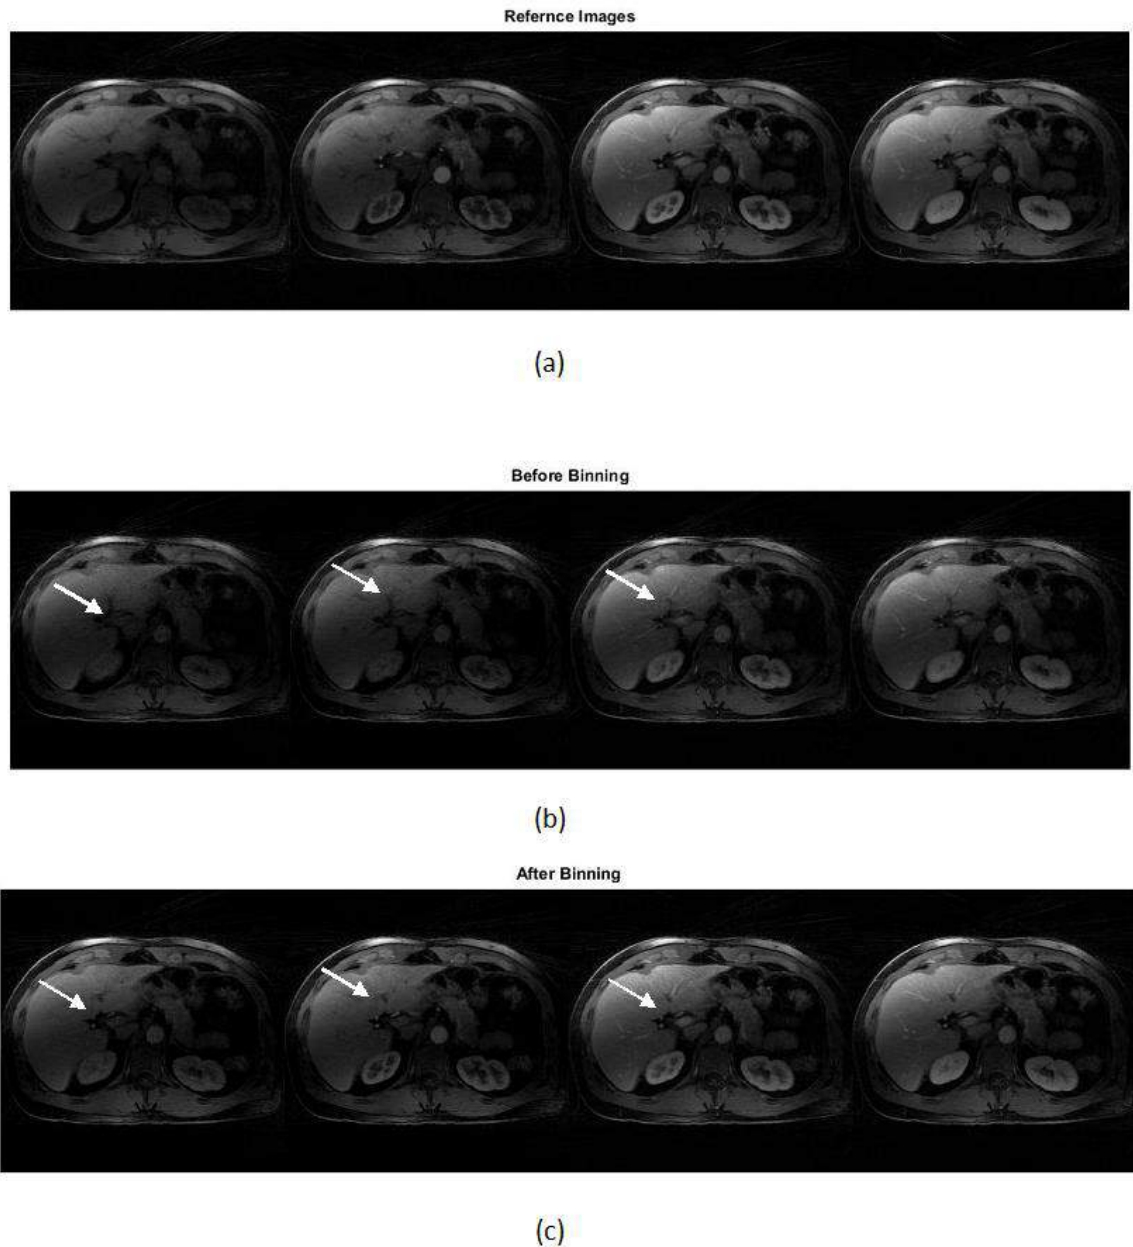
Qualitative comparison: reference images a) HL+S images b) and CL+S images c) for liver DCE MRI. Without binning recovery suffered from respiratory motion blurring effects. In contrast, the proposed method enabled improved reconstruction of all phases, better capture of the arterial phases, higher vessel clarity and sharpness.
